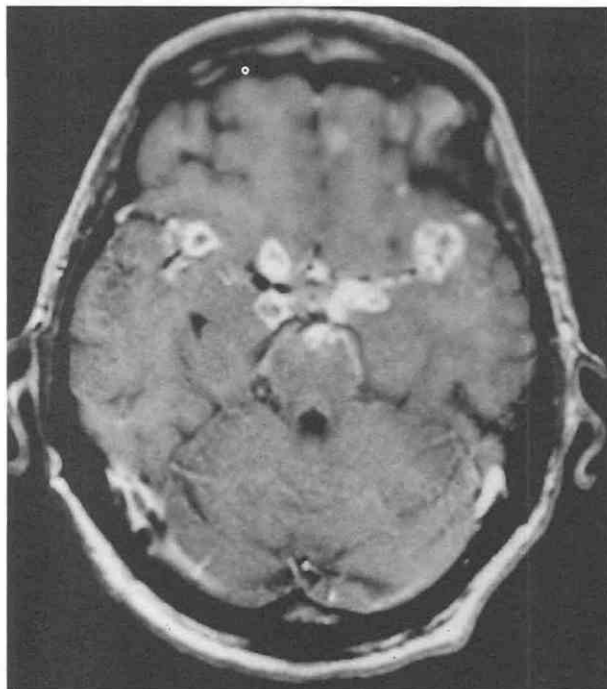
Multiple ring-enhancing tuberculomas are distributed throughout the perivascular spaces and basal pial surfaces on an axial T1-weighted image after administration of gadolinium.
